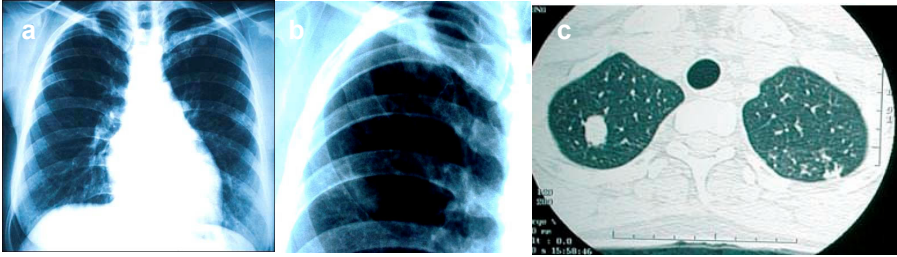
Simon nodule in upper lobe of the right lung in an asymptomatic adult. a and b: chest X-ray, c: computerized tomography.
